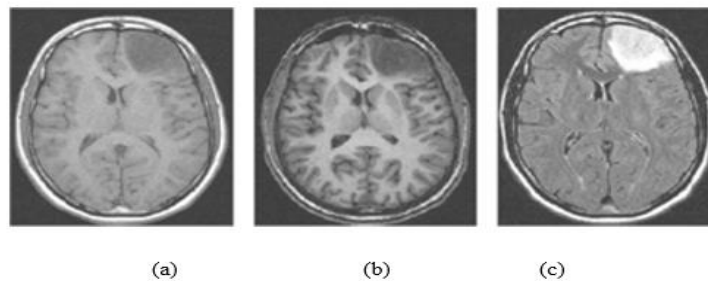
A tumor that is not increased. T1-weight axial slice (a). The identical T1-weight slice with contrast enhancement. b) The FLAIR image
